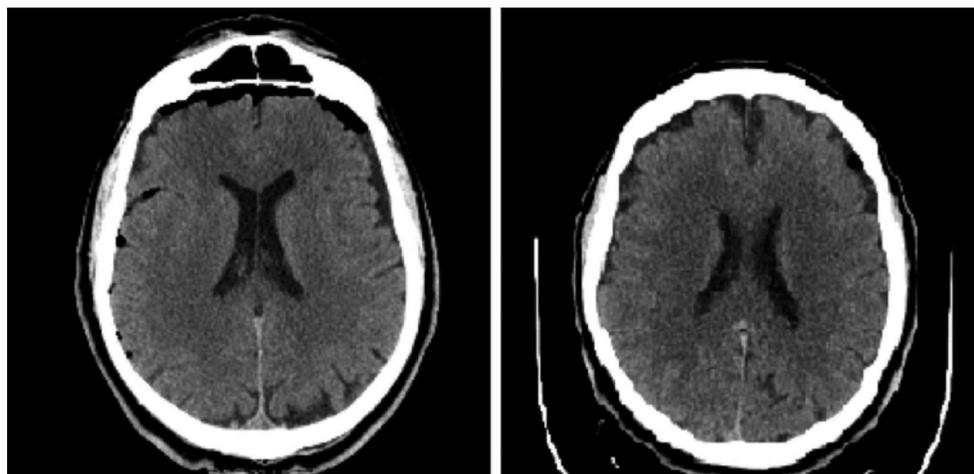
Postoperative axial brain CT-scans (day 0 and D +5).
